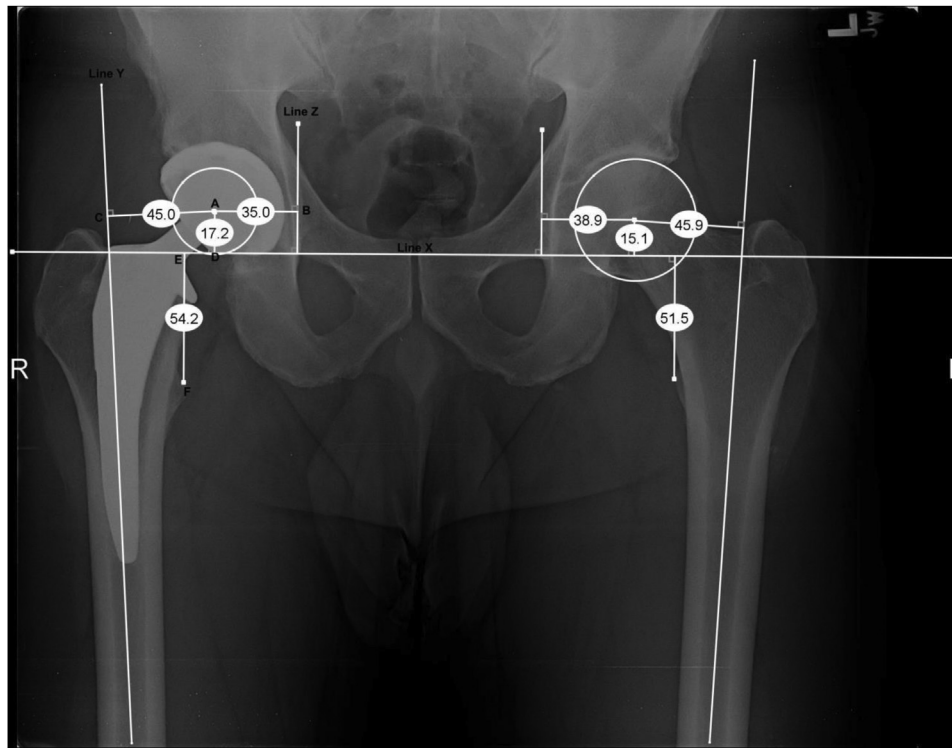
Radiographic Measurements of Hip Biomechanics. Line X represents the trans-teardrop line, intersecting the inferior portion of the teardrops. Line Z is perpendicular to line X at the medial aspect of the teardrop. Line Y runs through the anatomic axis of the femur. Point A is the center of the femoral head. Line AB is the horizontal component of the hip center of rotation. Line AD is the vertical component of the hip center of rotation. Line AC is the femoral offset. Lines AB + AC is the global offset. Line EF is the radiographic limb length.
